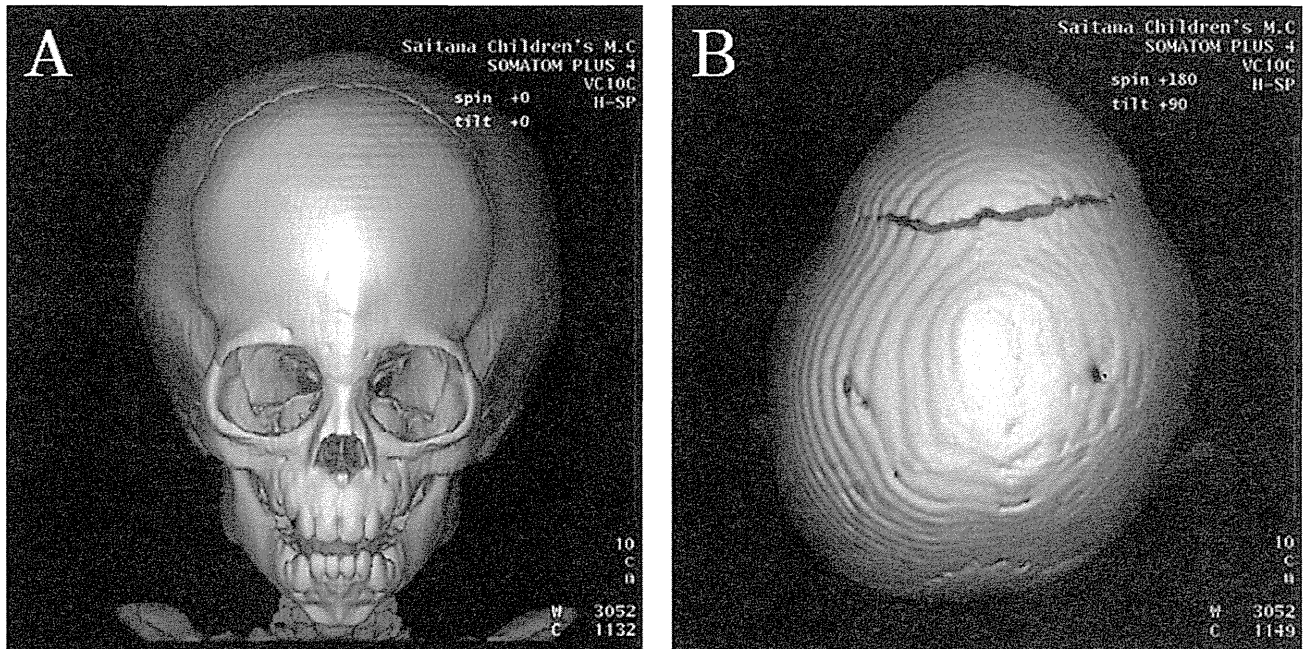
Frontal (a) and top (b) views of the skull of the patient at age 11 months showing trigonocephaly, reconstructed by three-dimensional computed tomography.
